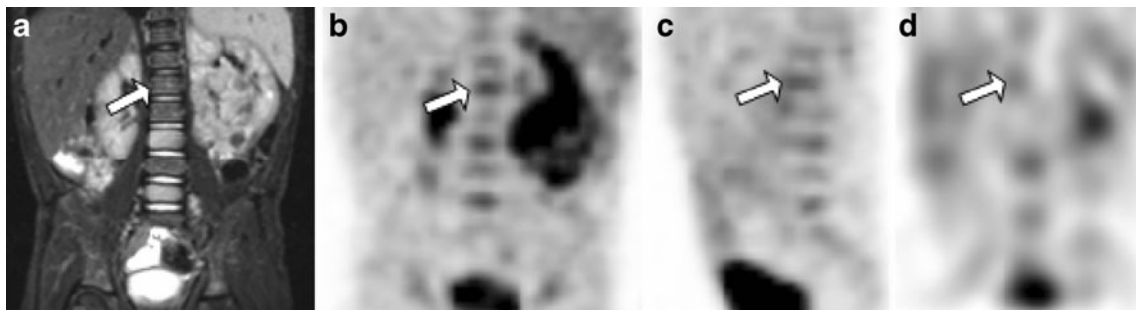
A 4-year-old boy at primary diagnosis of a left-sided neuroblastoma with a false-negative finding on MRI. On the MRI image (T2-weighted STIR sequence) suspect bone/bone marrow lesions were found in vertebral bodies L3 and L5. L1 (*arrow*) does
